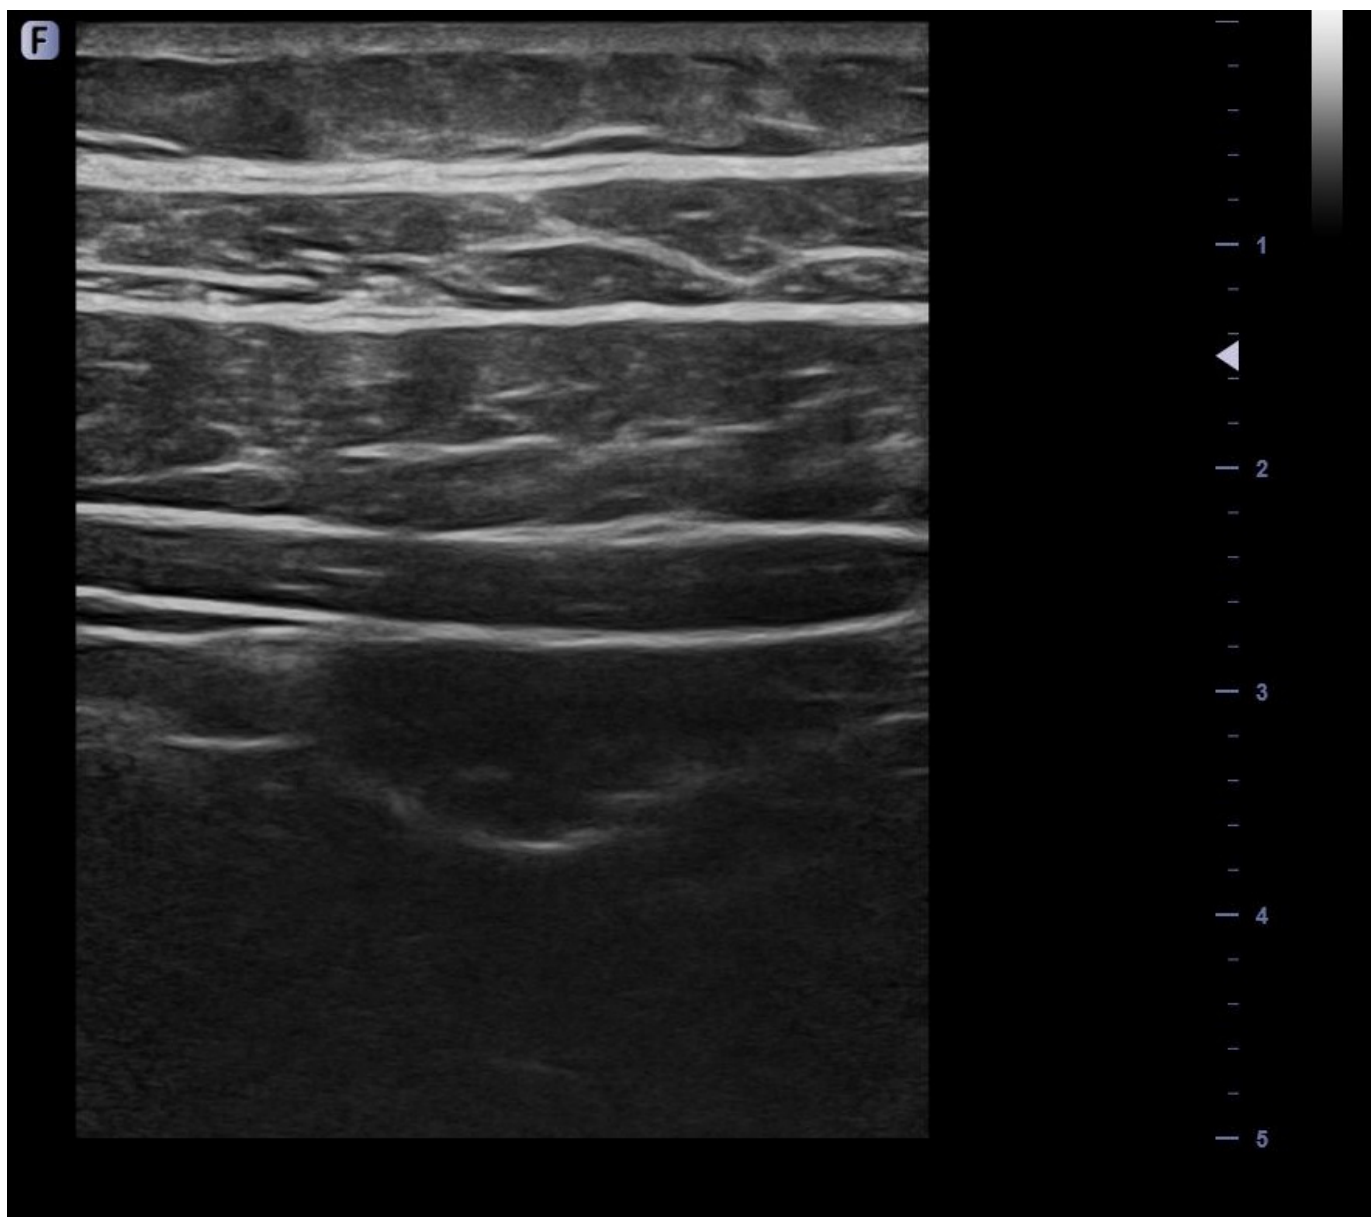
Ultrasound image of the lateral abdominal wall
